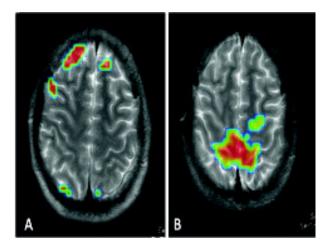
MRI imaging shows new areas of activation in the brain after stem cell therapy
